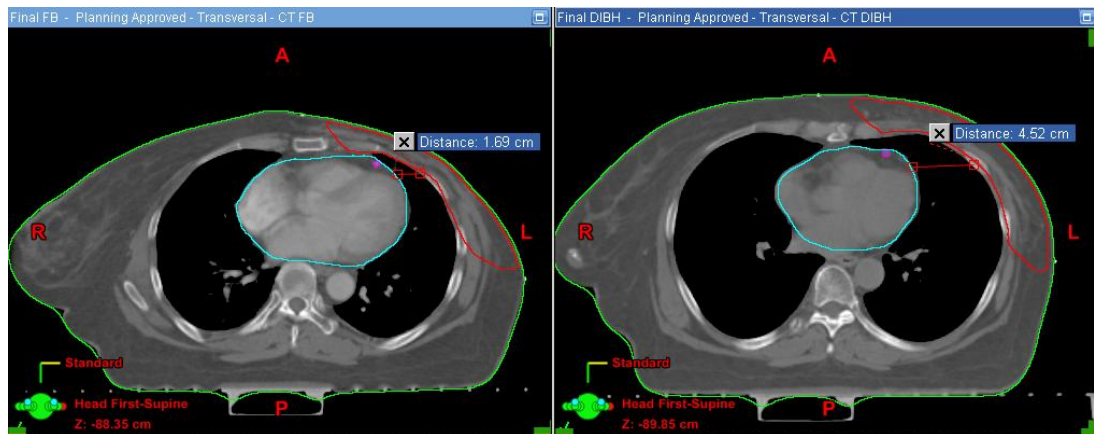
(B) CT images of the patient with good
